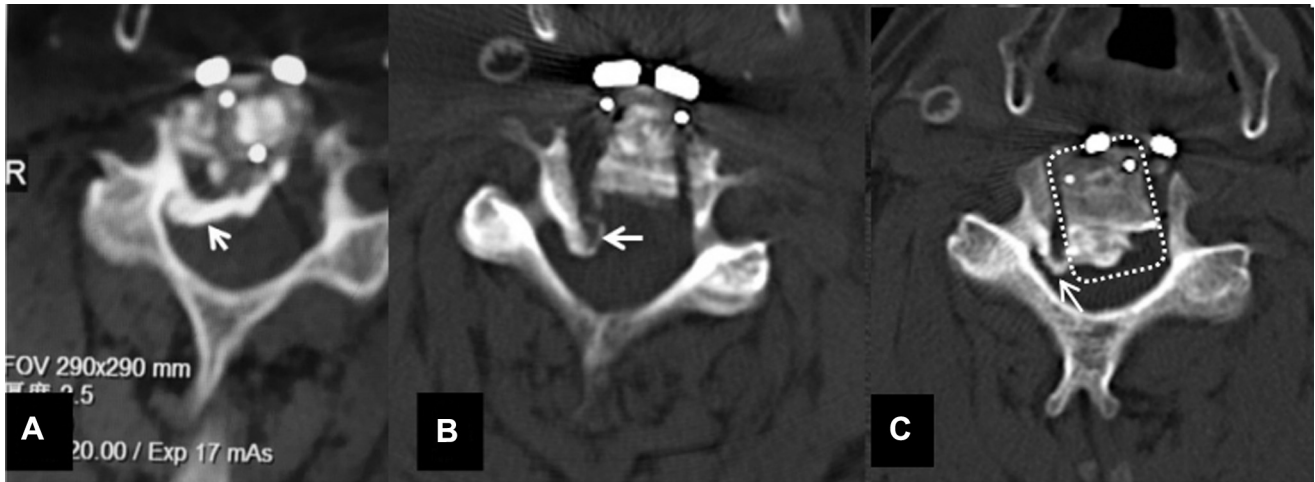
Cross-sectional computed tomography of cases with remaining ossification mass in the cervical canal. The *arrows* indicate the postoperative remaining ossification mass in the spinal canal (A and B). The *dashed line* indicates the vertebral-OPLL complex (C). OPLL, ossification of the posterior longitudinal ligament.
